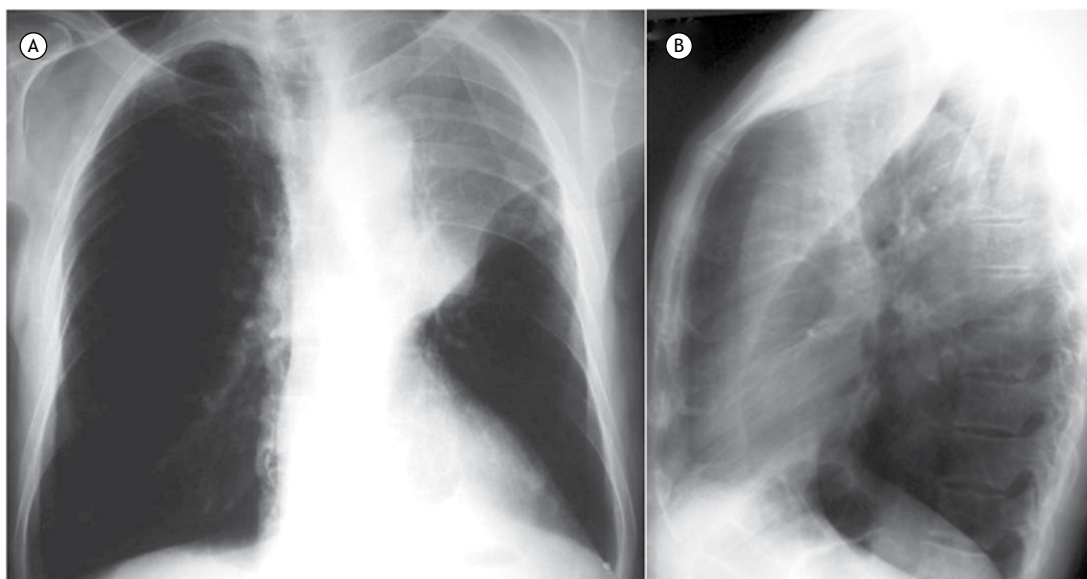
Posteroanterior and lateral chest X-rays (in A and in B, respectively) showing opacity and left upper lobe volume loss. Note an upward and forward shift of the major fissure and a mass in the left hilar region, preventing complete displacement of the fissure, which assumed an S shape (the Golden S sign).
